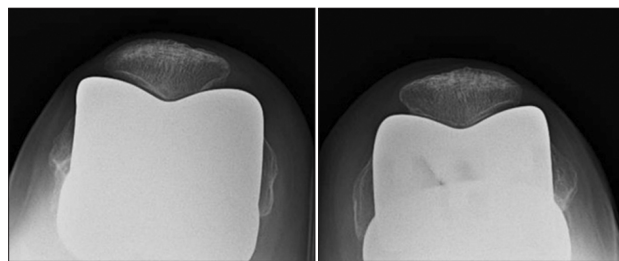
Skyline radiographs of a patient who underwent total knee arthroplasty using the Low Contact Stress system with patellar preservation. Note that the patella sits congruently on the femoral sulcus of the implant.
